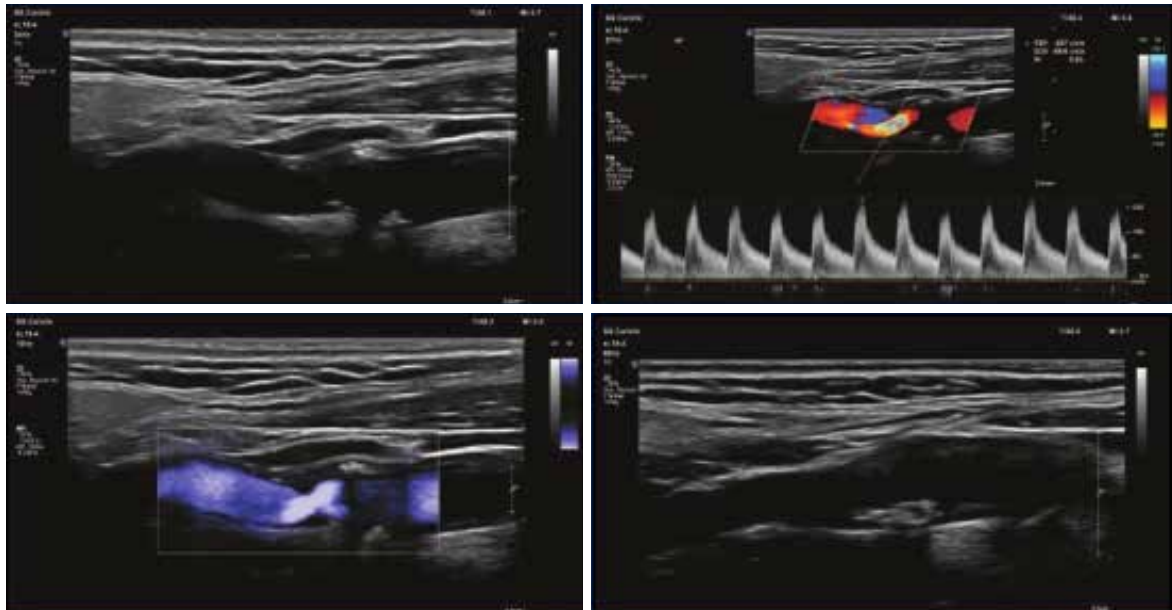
B-mode ultrasound of the origin of the left (above) and right (below) internal carotid artery with atherosclerotic plaques. Heterogenic echotexture with hypo- and hyperechogenic parts. Color Doppler ultrasound and pulsed wave Doppler of the left (above) and right (below) internal carotid artery.
